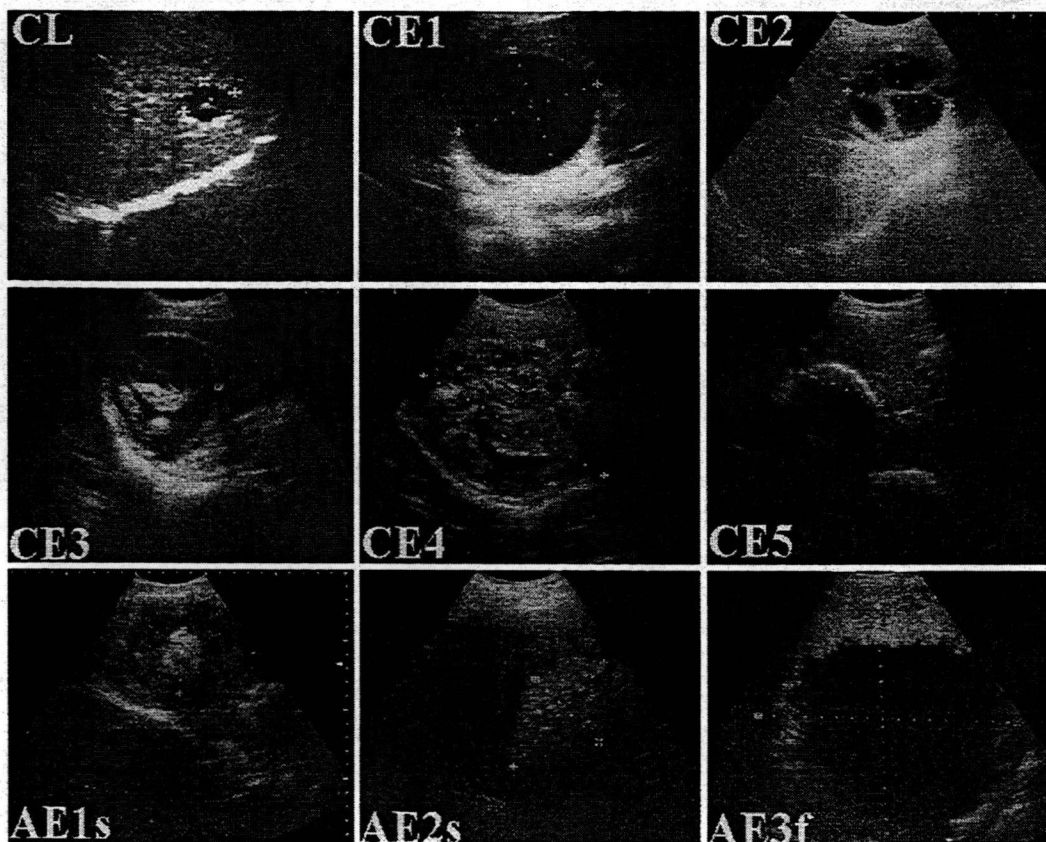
Ultrasound images of different types of hepatic echinococcal lesions in patients detected in northwest Sichuan.
